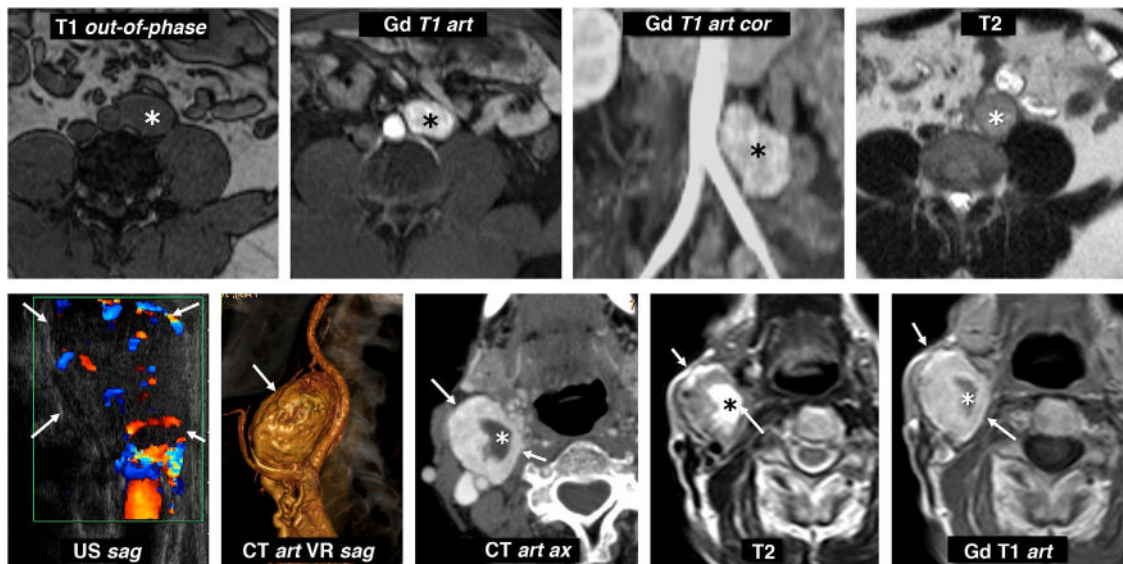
Extra-adrenal paragangliomas. Top row: metanephrine-producing sympathetic paraganglioma of the organ of Zuckerkandl. 31-year-old male investigated for hypertension and headache. Lobulated nodular lesion (*) located to the left of the distal aorta, immediately below the origin of the inferior mesenteric artery, in the anatomical location of the organ of Zuckerkandl. This lesion is isointense on T1-weighted images and maintains its signal out-of-phase, is hyperintense on T2 and enhances very intensely in the arterial phase with Gadolinium. Bottom row: non-secretory parasympathetic paraganglioma of the carotid glomus. 46-year-old male. Consultation for palpable mass in neck. Intensely vascularised isoechoic nodular lesion (arrows) next to the right carotid bifurcation (the ultrasound image has been rotated 90° for better correlation). CT scan shows an intense enhancement, with some cystic foci inside (*). On MRI, solid areas show high signal on T2 and intermediate on T1, with intense and rapid enhancement. The cystic areas behave like water. Catecholamine determinations were normal.
